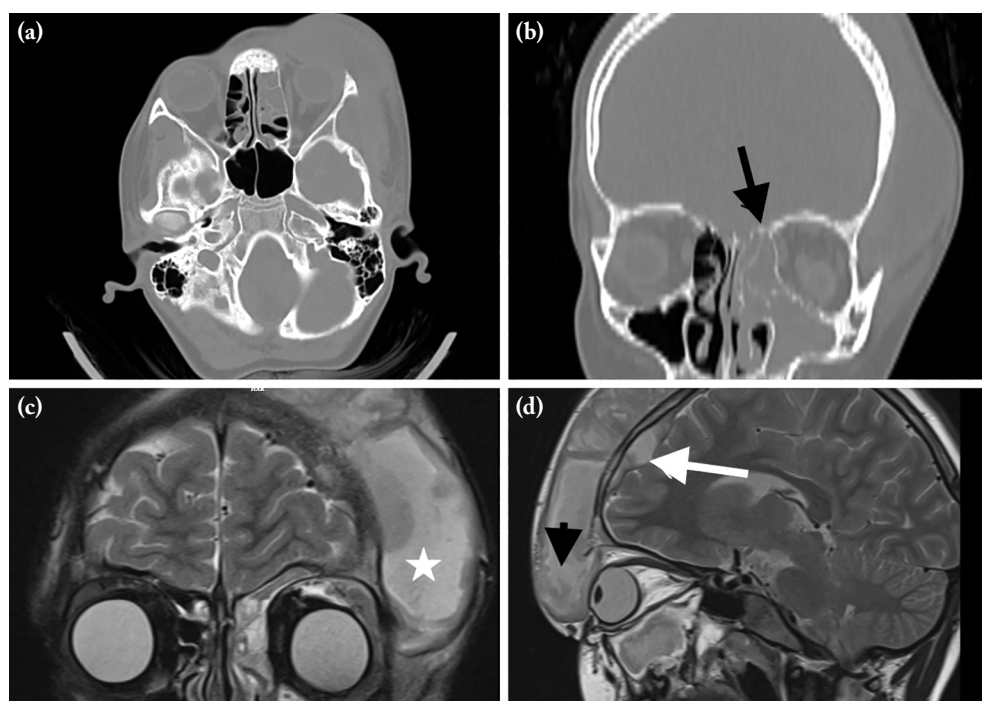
(a) Axial CT image. (b) Coronal CT image. (c) Coronal MRI image. (d) Sagittal MRI image. Radiological images of a patient with left-sided acute pansinusitis (b, black arrow) complicated by a preseptal abscess causing orbital compression (d, black arrowhead), an extensive frontoparietotemporal subperiosteal abscess (c, asterisk), a frontal epidural empyema (d, white arrow), and imaging findings suggestive of frontal osteomyelitis (b). MRI, magnetic resonance imaging; CT, computed tomography.
